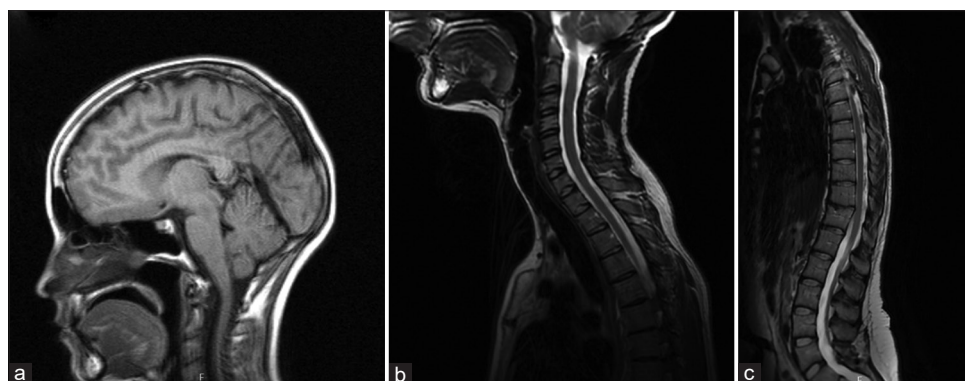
Case 5 imaging - Tethered cord release. (a) Preoperative T1-weighted sagittal MRI brain demonstrating 5 mm of tonsillar herniation below the foramen magnum and anterior kinking of the brainstem from the mild basilar impression and C2 pannus. (b and c) Postoperative T2-weighted sagittal cervical MRI 64 months after the initial operation and 36 months after tethered cord release demonstrating expected postoperative changes. MRI: Magnetic resonance imaging
